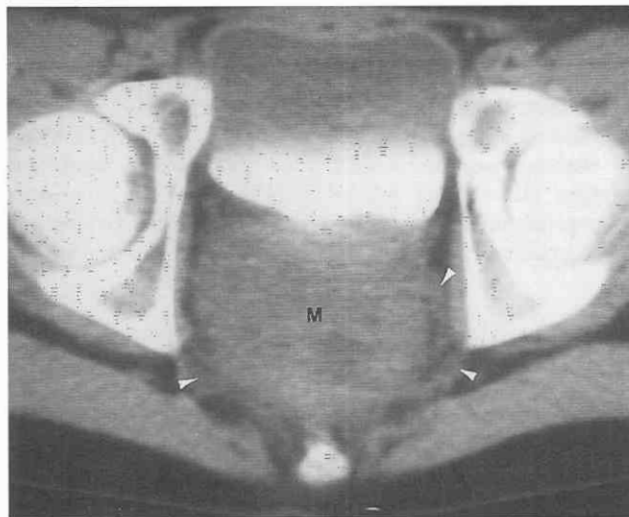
Vaginal rhabdomyosarcoma in a 13-year-old girl with vaginal bleeding. CT scan shows a bulky, soft tissue mass (M) that expands the vagina and infiltrates the pelvic fat (arrowheads).
